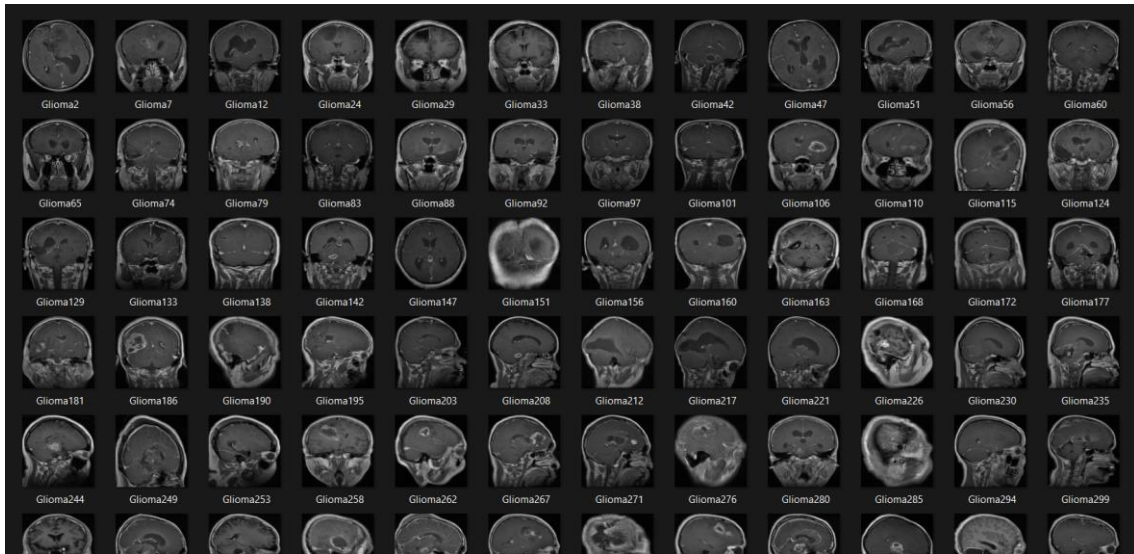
Glioma Brain MRI
